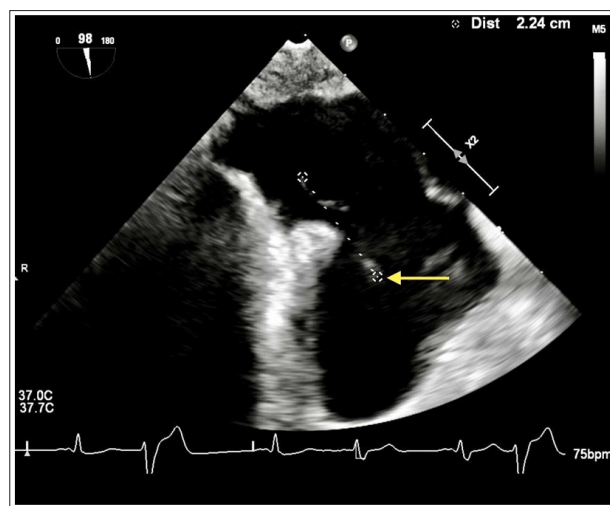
Transesophageal Echocardiogram showing the serpentine shaped attachment (yellow arrow) to the Chiari-Eustachian valve complex within the right atrium
